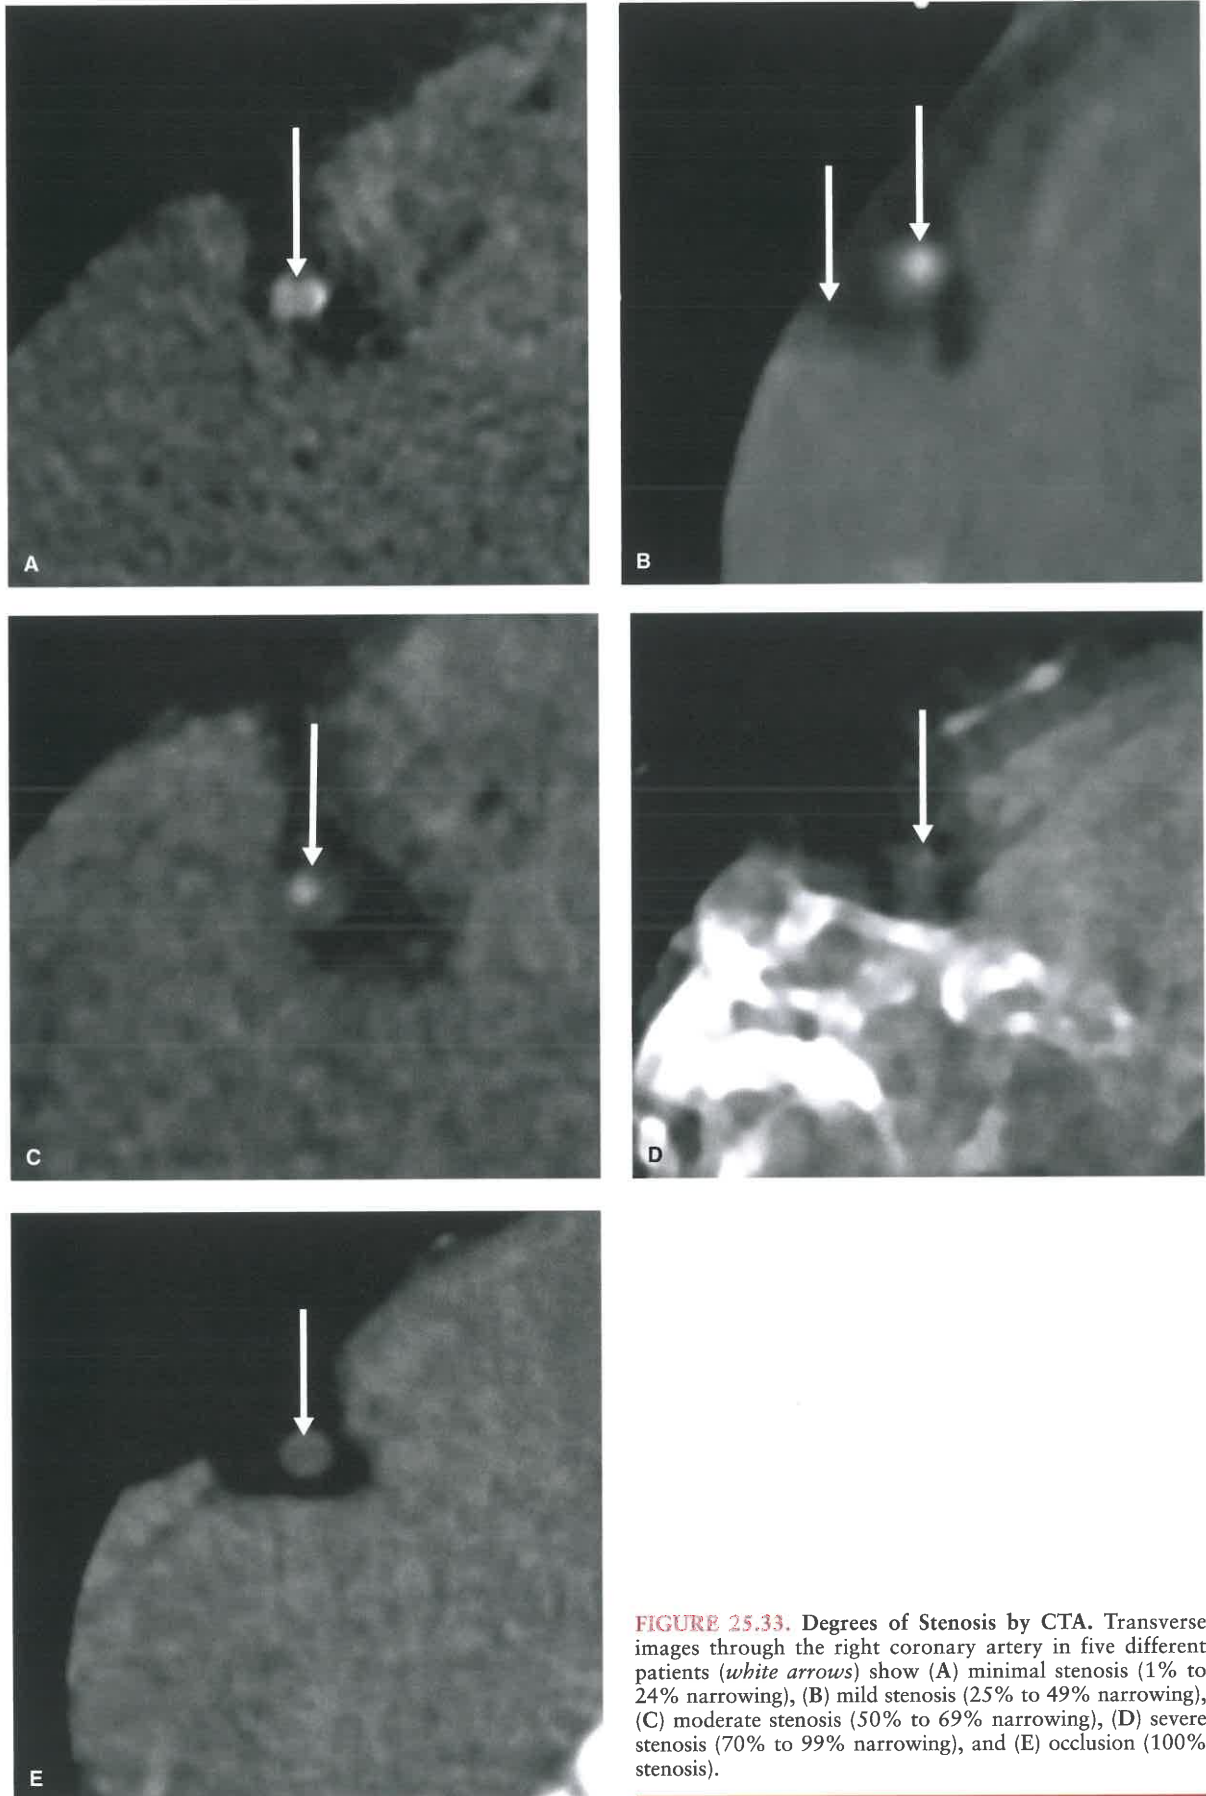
Degrees of Stenosis by CTA. Transverse images through the right coronary artery in five different patients (*white arrows*) show (A) minimal stenosis (1% to 24% narrowing), (B) mild stenosis (25% to 49% narrowing), (C) moderate stenosis (50% to 69% narrowing), (D) severe stenosis (70% to 99% narrowing), and (E) occlusion (100% stenosis).
